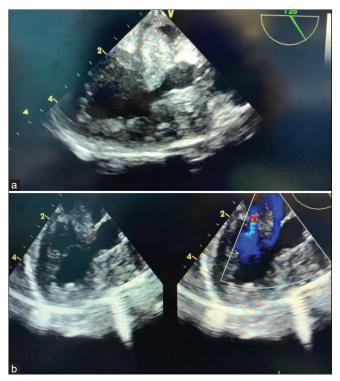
(a and b) Transesophageal echocardiogram showing a mass/thrombus in the left atrium, prolapsing across the mitral valve
